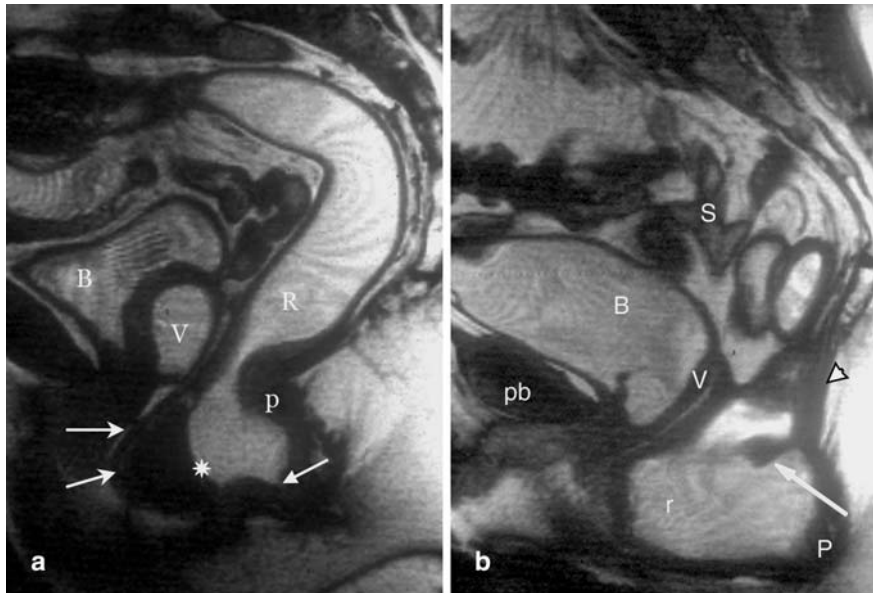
a A 61-year-old woman with a history of urinary incontinence and fecal soiling. Midsagittal T2-weighted true fast imaging with steady-state progression image with the patient straining. During the straining maneuver there was a ventral bulging of the rectal wall together with the lower third of the dorsal vaginal wall (arrows). The classical appearance of an anterior rectocele is shown (star) without relaxation of the puborectalis sling (*P*) and with partial opening of the anal canal (arrowhead). *B* Bladder; *V* vagina (filled with sonogel); *R* rectum. b A 56-year-old woman with a long history of evacuatory difficulty. Midsagittal T2-weighted true fast imaging with steady-state progression image with the patient straining. This almost 6-cm-deep anterior rectocele (*r*) developed only after several attempts to defecate. Other findings include the anorectal junction (*p*), which descended well below the level of the inferior pubic rim (*pb*) and the posterior part of the levator ani muscle, which shows a steep angle (arrowhead). In addition, there is a bulging of the posterior rectal wall (arrow). These findings are typical in patients with outlet obstruction/constipation and descending perineum syndrome. *B* Bladder; *V* vagina; *S* small bowel loops
